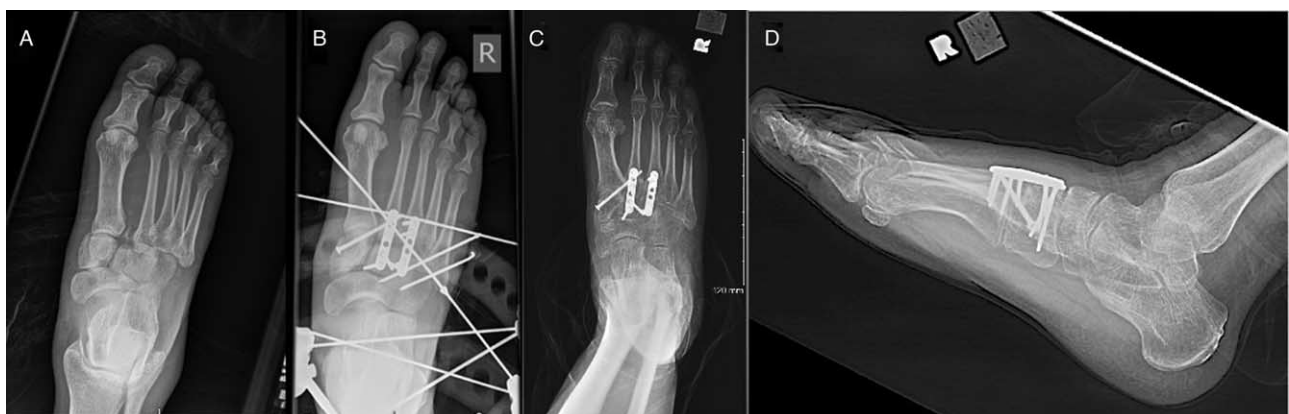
Case 2, midfoot injury. (A) AP x-ray of injury. (B) Postoperative AP x-ray. (C) AP x-ray at 1 year postoperatively. (D) Lateral x-ray at 1 year postoperatively.
